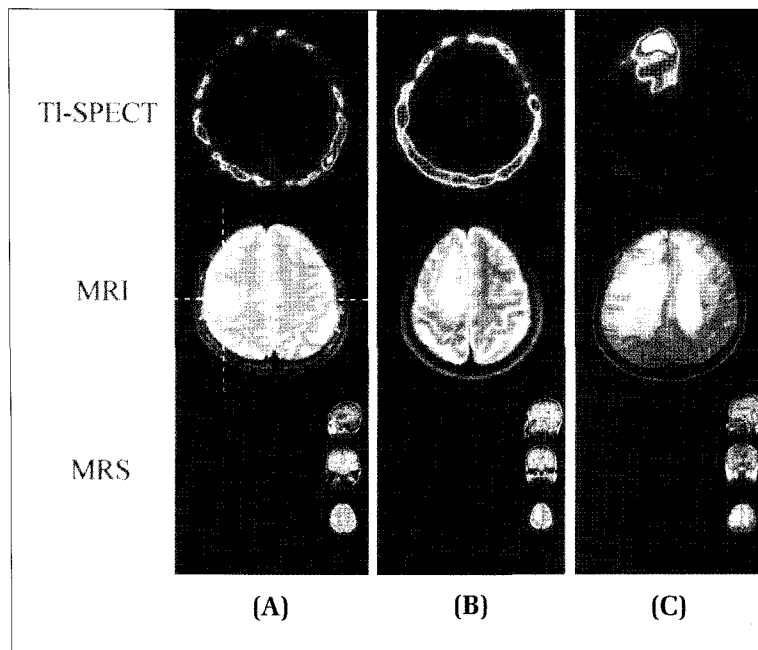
Typical ^{201}Tl SPECT images. From left to right: images of astrocytoma (patient No. 13), anaplastic astrocytoma (patient No. 10) and glioblastoma (patient No. 3) are demonstrated. (top) ^{201}Tl SPECT, (middle) T2-weighted MR images, and (bottom) ^1H MRS.
